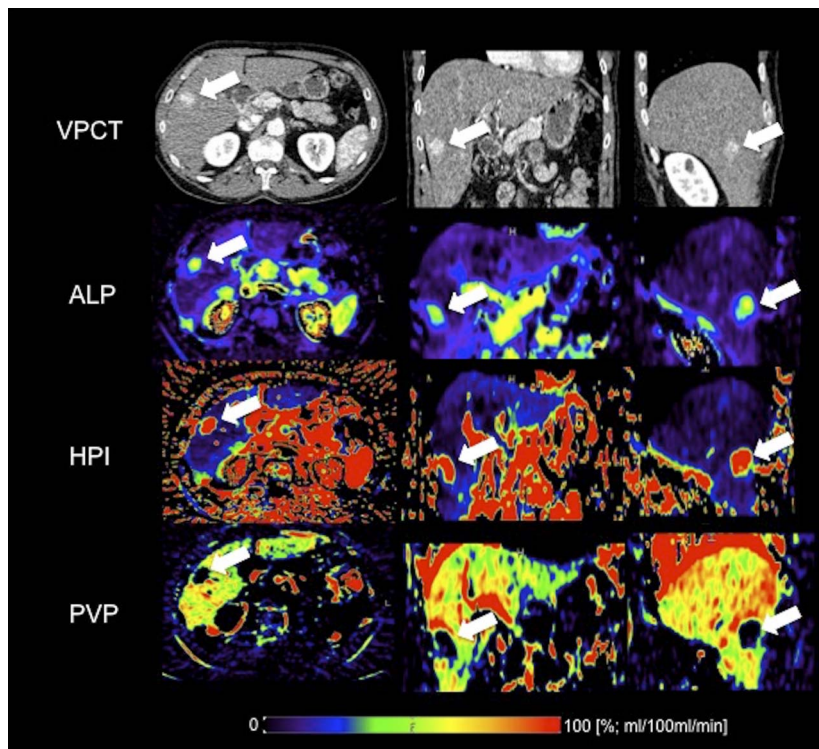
Corresponding VPCT images and perfusion maps to Figure 2 of a 54-year-old male patient with a hepatocellular carcinoma (arrow) before TACE. The target lesion is clearly visible in the VPCT images and the perfusion maps. VPCT, volume perfusion computed tomography; TACE, transarterial chemoembolization; ALP, arterial liver perfusion [mL/100 mL/min]; HPI, hepatic perfusion index [%]; PVP, portal liver perfusion [mL/100 mL/min].
